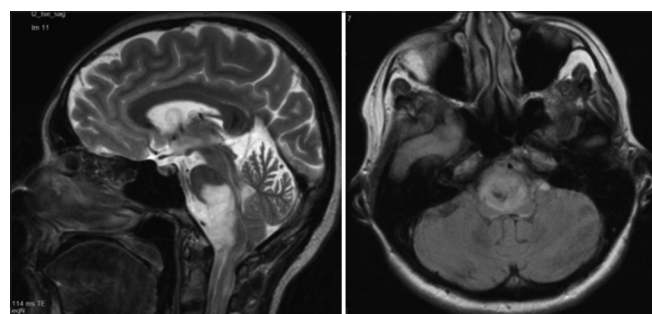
Axial and sagittal T2-weighted magnetic resonance images of brain stem glioma
